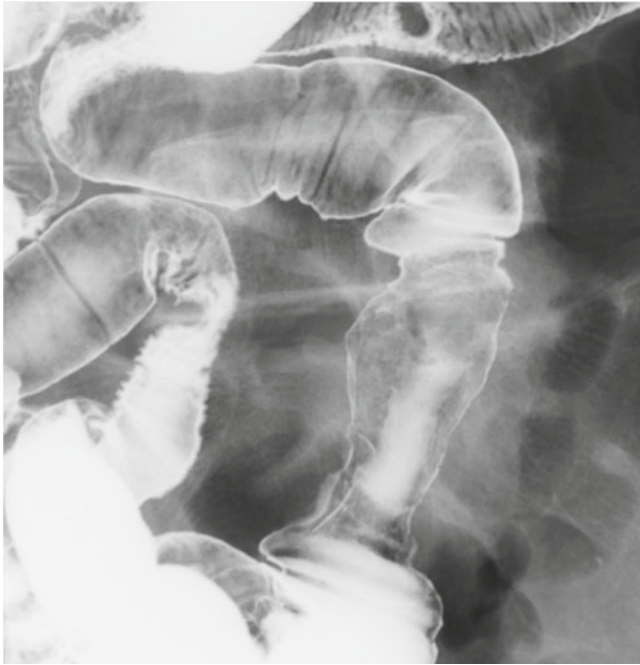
Radiography showed an elevated lesion with gradual marginal rising appearance in the ileum, with luminal stenosis and ulceration inside. Distensibility of the lumen was comparatively good, with no rigidity
